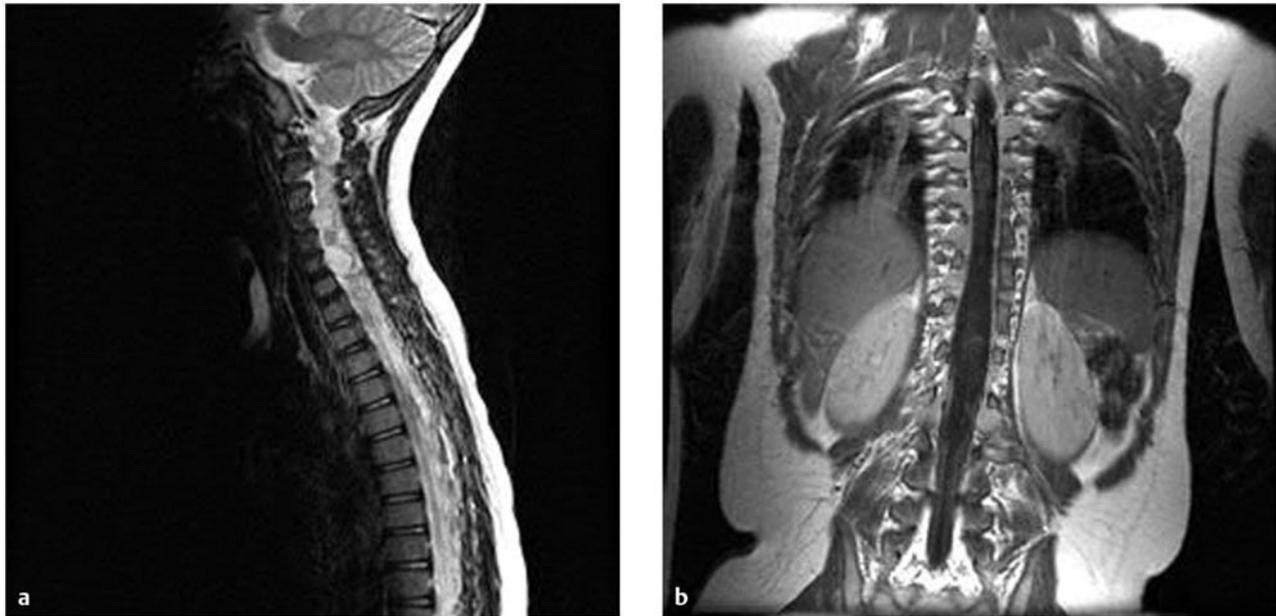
(a) Sagittal and (b) coronal gadolinium-enhanced magnetic resonance images of the cervical and thoracic spine of a 6-year-old girl with neurofibromatosis demonstrate multiple enhancing tumors involving most nerve roots of the cervical and thoracic cord.
